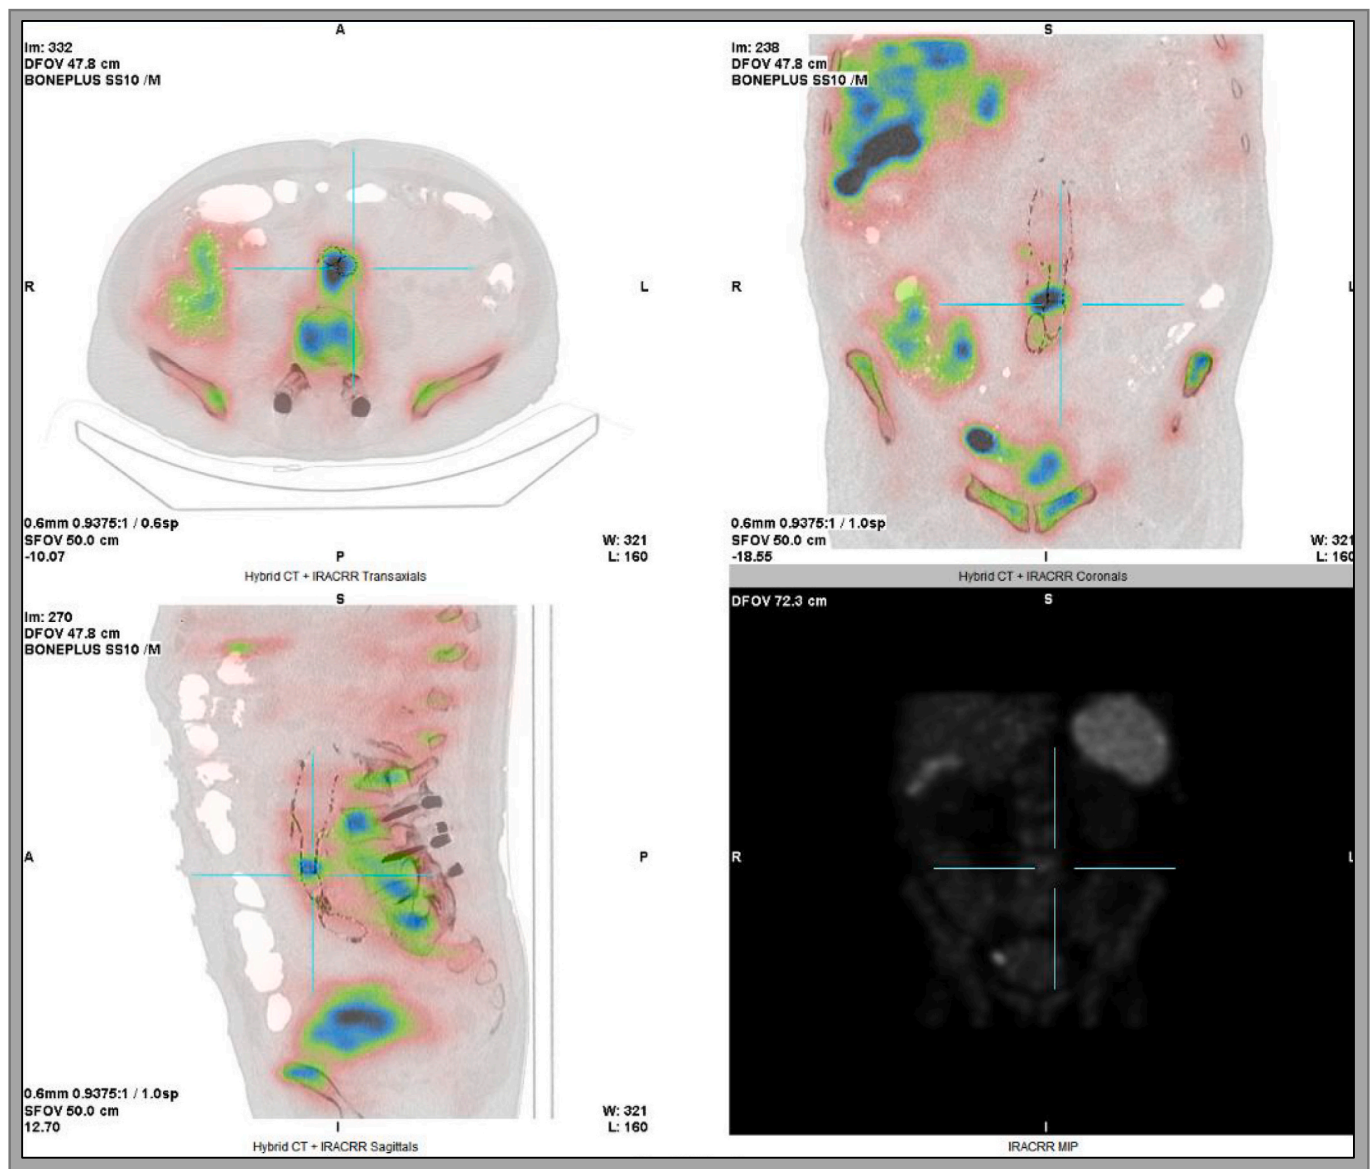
^{99m}Tc-HMPAO-labeled WBC scintigraphy. There is accumulation of labeled WBCs at the aortoiliac bifurcation. WBC, white blood cell.
